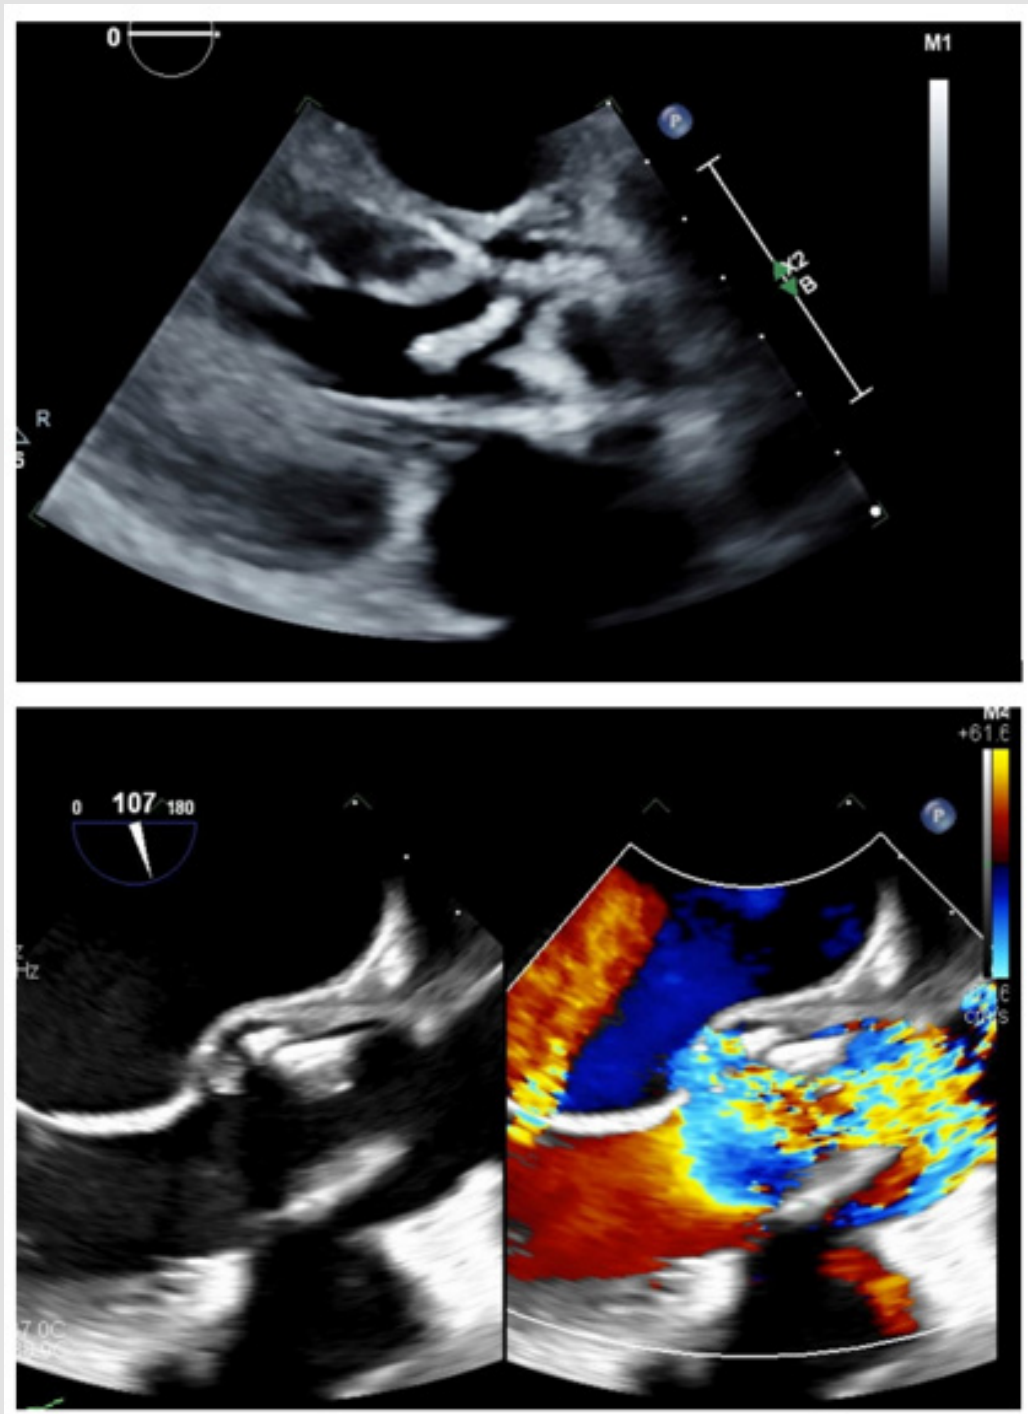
Transthoracic echocardiogram images with color doppler showing valve dehiscence.
